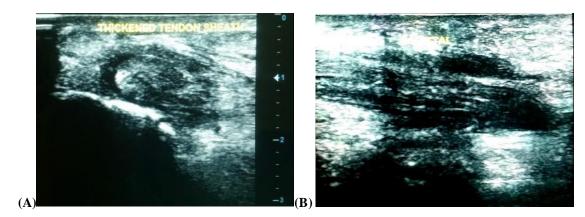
A, axial and B, longitudinal ultrasound scan shows diffuse swelling with increase caliber and surrounded fluid distending the tendon sheath.
